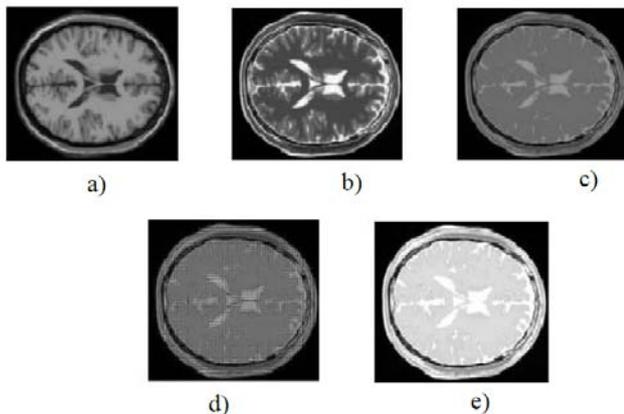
Fusion results for Normal brain, (a) MRI-T1 image, (b) MRI-T2 image, (c) PCA fusion, (d) CDF9/7 DWT based fusion, (e) proposed fusion method
